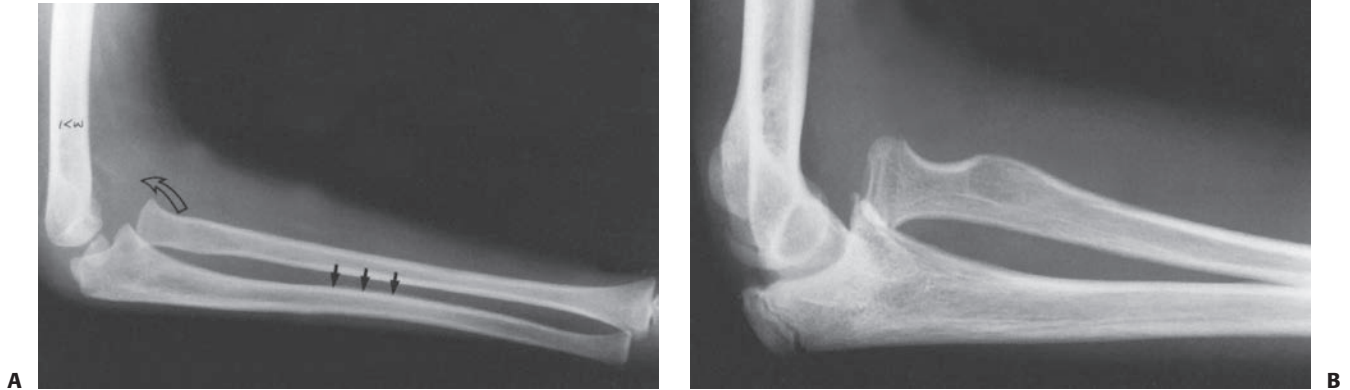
Chronic Monteggia lesion with ulnar bow line. A: The injury radiograph of an 8-year-old girl who fell, spraining her arm. Note the anterior bow of the ulna (*black arrows*) and loss of the radiocapitellar relation (*open arrow*). The diagnosis of a Monteggia lesion was not established. B: Radiograph at time of late diagnosis. Note the persistent ulnar bow and overgrowth of radius.
